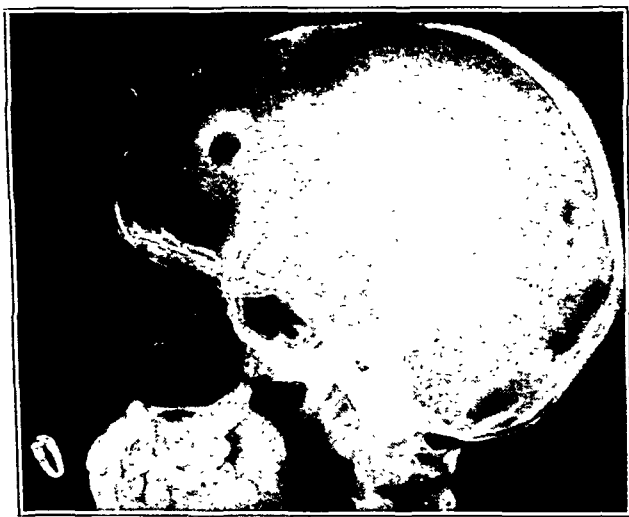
(case 1).—Roentgenogram of right lateral view of the skull showing the defect in the right frontal region characteristic of a diploic epidermoid.
